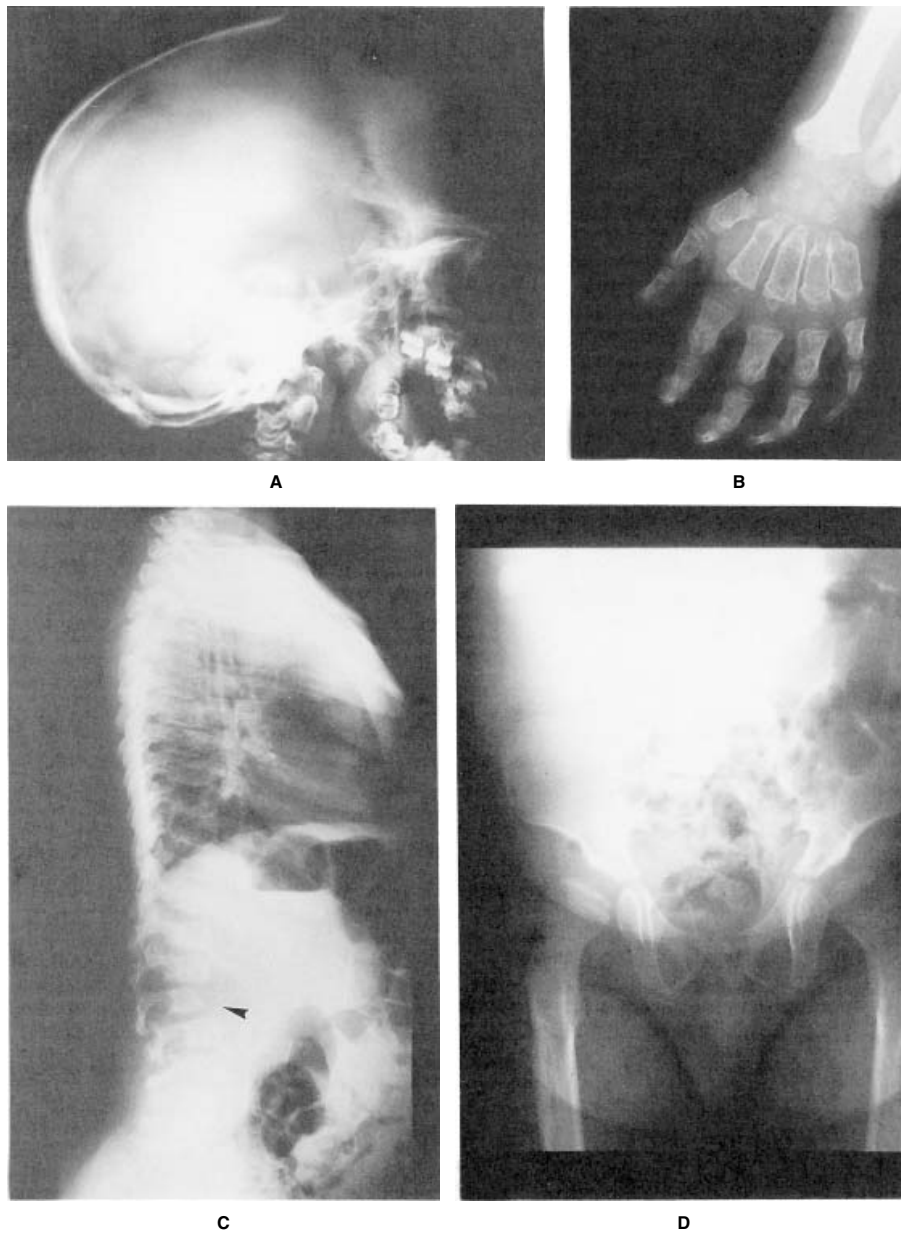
Roentgenographic dysostosis multiplex in fully developed MPS IH as documented at 7 3/12 years in the patient shown in Figure 1. A: Enlarged cranial vault with elongated sella turcica. B: Left hand and wrist: tilted, irregular distal radial and ulnar metaphyses; dysplastic small carpal bones; metacarpals with proximal pointing, widened diaphyses, and coarse trabeculation; phalanges shortened and widened; claw hand deformity shown by flexion of fingers. C: Spine; small L₃, with anterior–inferior beaking (arrow). D: Pelvis: narrow iliac bodies and flaring wings; oblique, shallow acetabula; coxa valga; flattened proximal femoral epiphyses.
